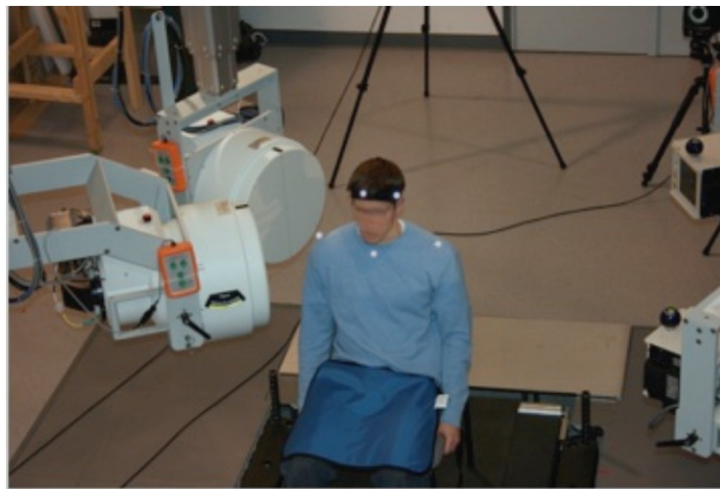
Biplane X-ray data collection system.
